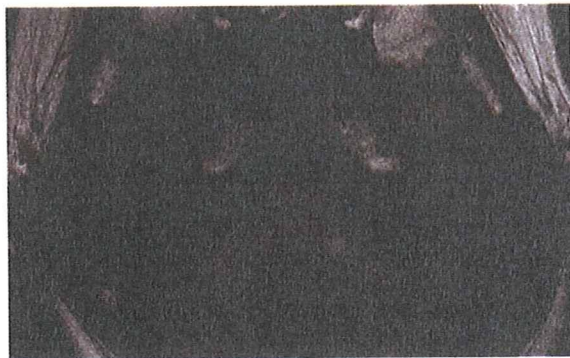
Axial magnetic resonance image of the right inner ear of a 39-year-old woman with Ménière's disease. Three-dimensional fluid-attenuated inversion recovery magnetic resonance image taken 1 day after intratympanic injection of Gd. The high signals of the cochlea are not visible. We injected Gd intratympanically into the same ear again, but the MRI showed no movement of Gd into the inner ear.
